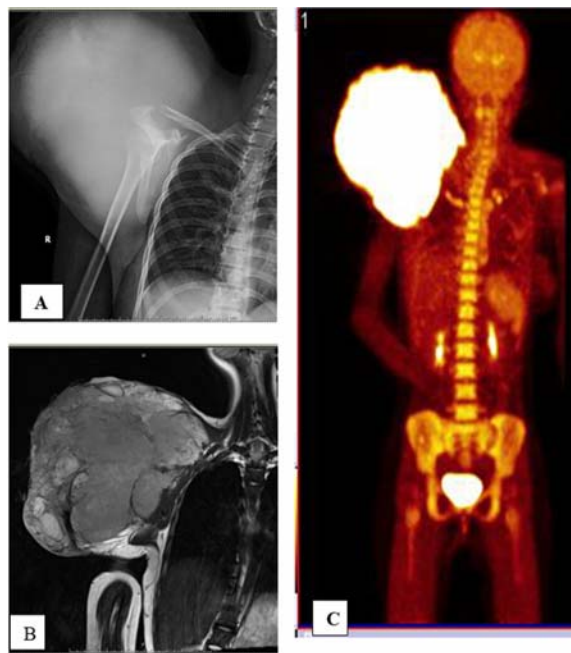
Imaging findings. A) A plain radiograph showed a large soft tissue mass overlying the right scapula and a faint osteolytic lesion at the body of the right scapula and acromial process. B) Magnetic resonance imaging of the shoulder showed iso-intensity on T1-weighted imaging and high signal intensity on T2-weighted imaging with heterogeneous enhancement. A 26- x 18- x 23-cm soft tissue mass was observed at the right scapula. C) Positron emission tomography/computed tomography showed an abnormal hypermetabolic enhancing mass at the right scapula.
